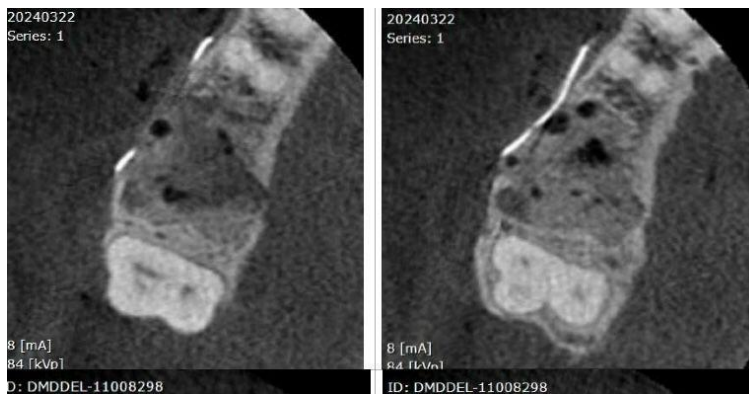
CBCT immediately after grafting
